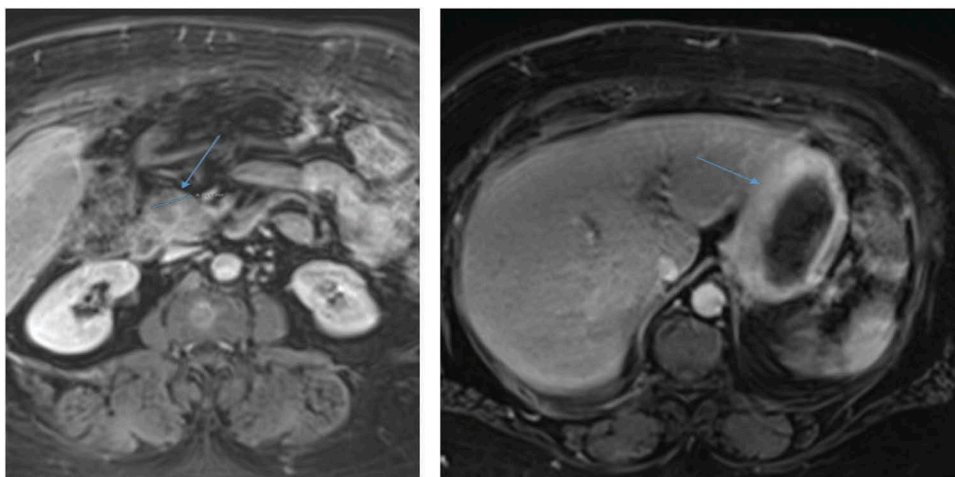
Left: MRI image of solitary 3.5cm mass in uncinus process of pancreas (arrow). Right: MRI image of diffusely thickened stomach wall (arrow).
